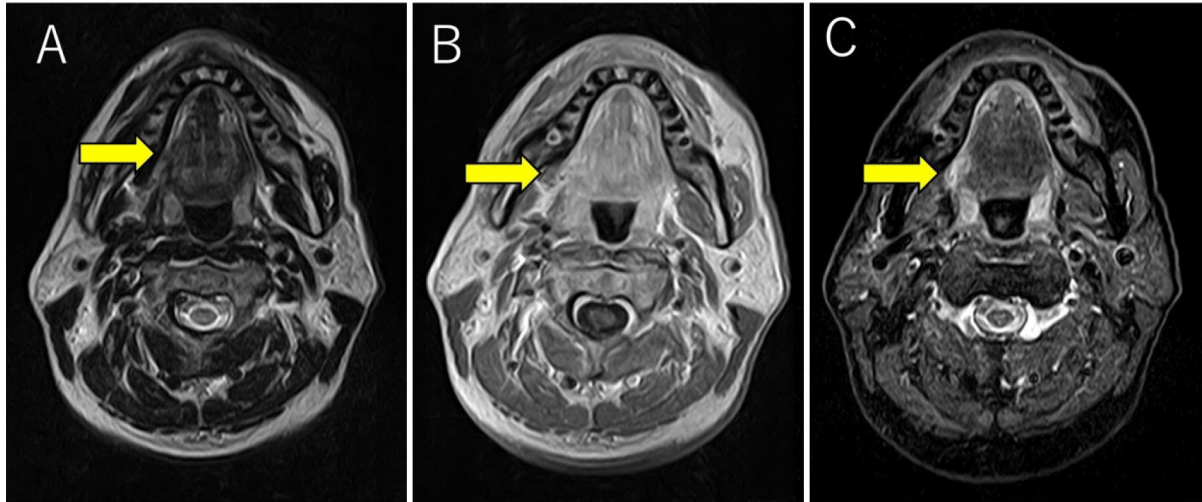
Magnetic resonance imaging (MRI) characteristics of the tumor on the right side of the tongue. MRI showed low signal intensity on T2-weighted images (arrow) (A), high signal intensity on T1-weighted (arrow) (B) and short tau inversion recovery (arrow) (C) images, and an area of heterogeneous contrast in the right side of the base of the tongue.
